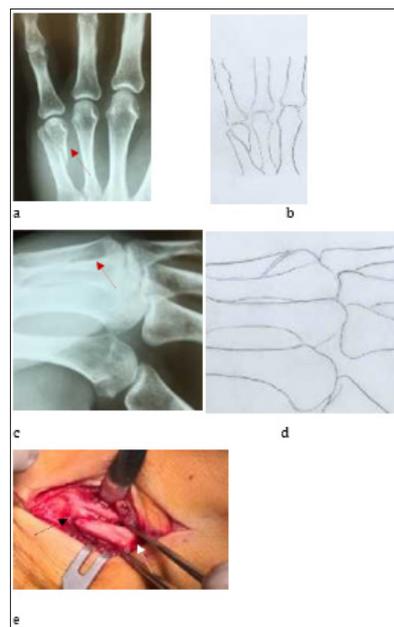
Type III fracture, x-Rays (red arrow) AP (a,b), Oblique (c, d), surgical evidence (black arrow oblique fracture of 5th metacarpal, white arrow head of metacarpal) (c).
